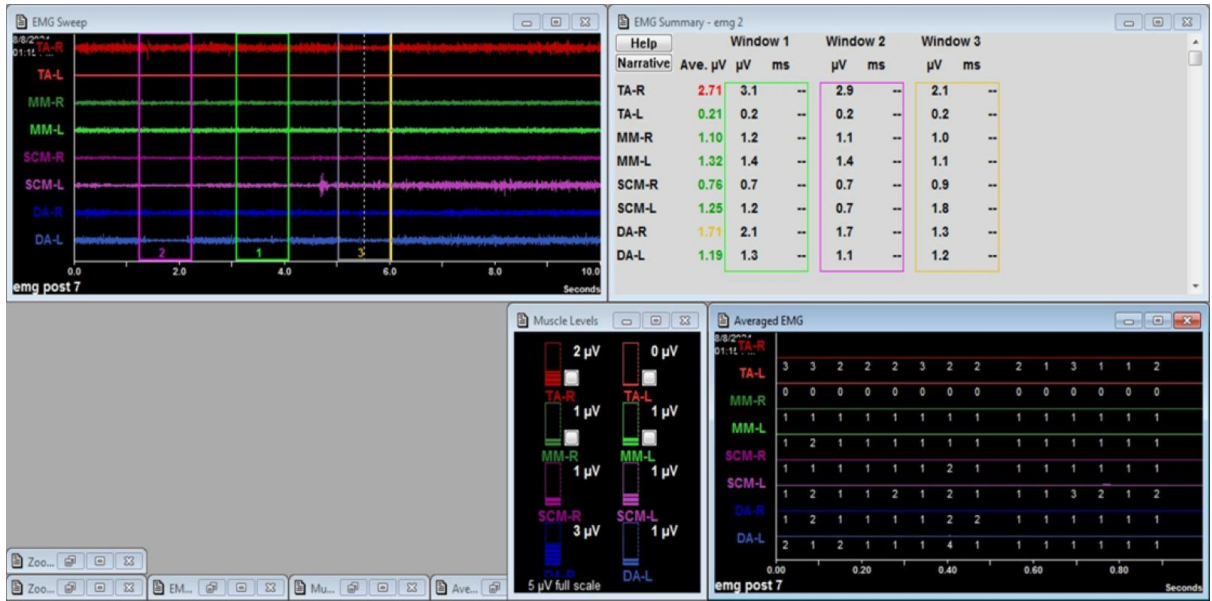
ultrasound therapy
